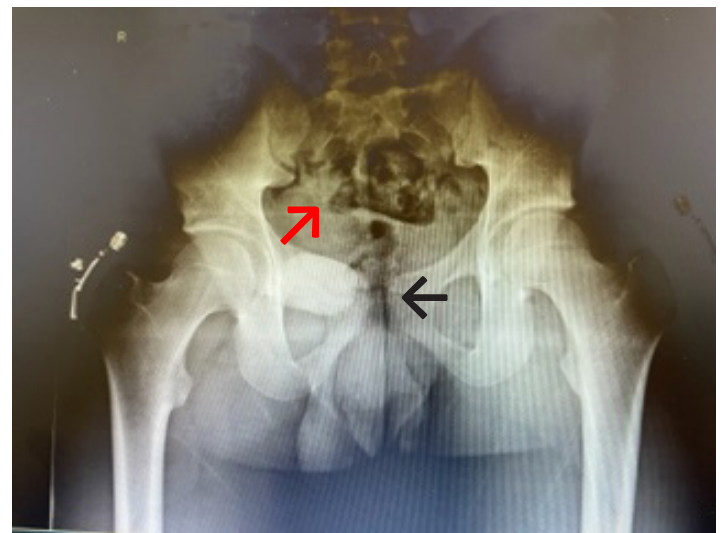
Magnetic resonance image of the 18-year-old male patient: rare location of ABC –Right pubic (black arrow) and sacrum (red arrow) regions.
